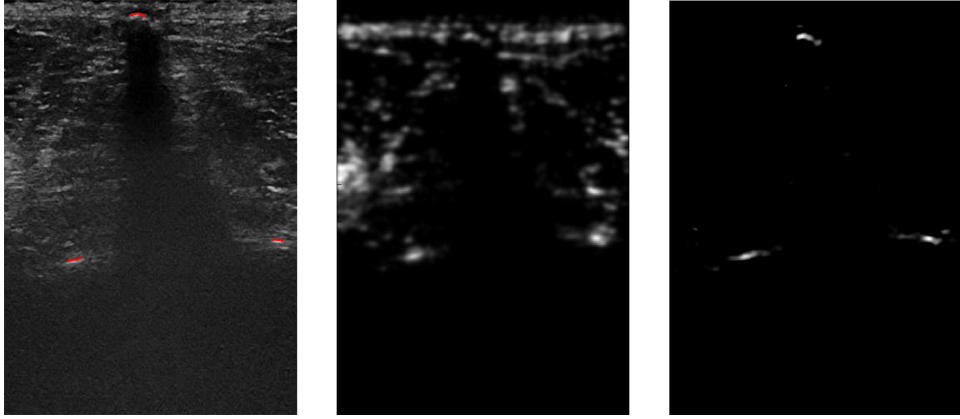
An ultrasound image of a vertebra with the segmentation overlaid in red (left), the initial bone probability map (centre) and the final bone probability map after applying the threshold (right).
